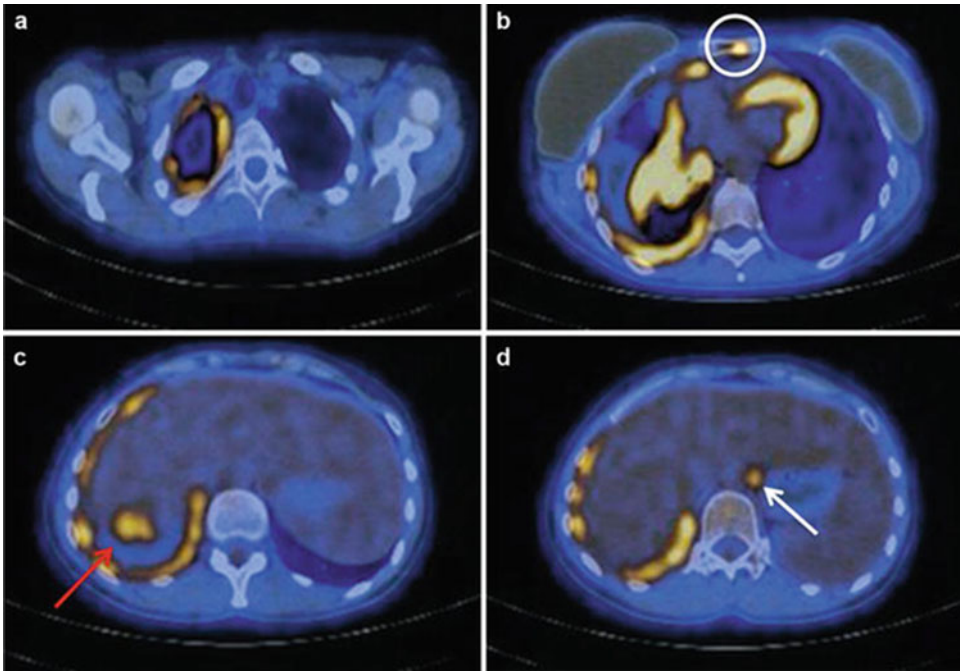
Fused transaxial PET/CT images show pathological pleural [¹⁸F]FDG uptake (a–d), sternal [¹⁸F]FDG-avid lesion (b, white circle), liver metastasis (c, red arrow), and abdominal lymph node involvement (d, white arrow) consistent with distant metastatic recurrence of breast cancer
